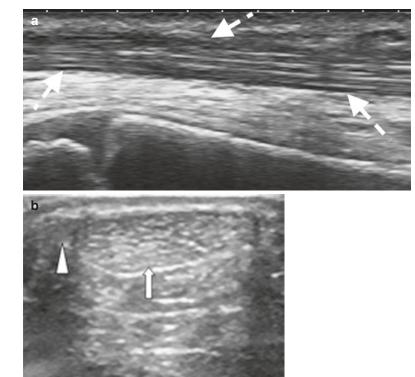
Ultrasound of the tendon: (a) longitudinal ultrasound of the tibialis anterior with normal fibrillar pattern and (b) transverse US image of the oval Achilles tendon (A) (*arrow*) and adjacent plantaris tendon (*arrowhead*) medially; the paratenon is identified as the thin hyperechoic rim surrounding the AT
